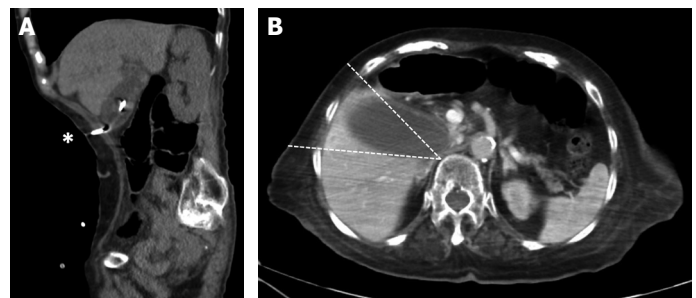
(A) Transperitoneal (*) percutaneous cholecystostomy in cachexia and irregular respiration prevented the visualization of optimal ultrasonography for guidance. (B) Approach zone in percutaneous cholecystostomy (white lines). The entry was accomplished from a zone that is located between the right mid-axillary and right mid-clavicular lines.
